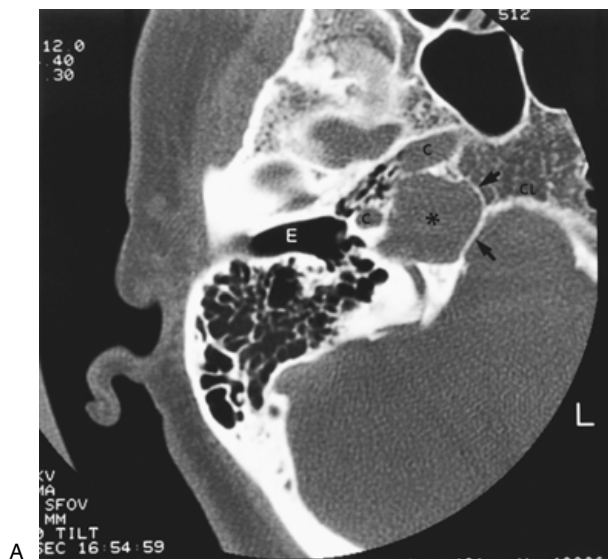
Cholesterol granuloma. (A) Axial computed tomography (CT). (B) Sagittal T1-weighted magnetic resonance imaging (MRI). There is a well-circumscribed rounded lesion in the right petrous apex (asterisk). The thin but intact cortical margin on CT (arrows) indicates the slow expansile character of the lesion that allows
